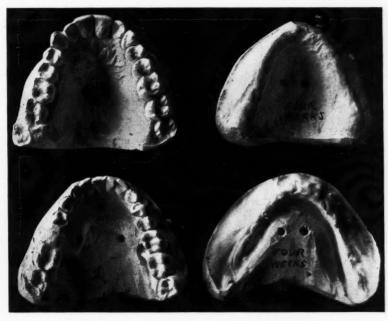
Surgical preparation in a case of periapical disease.
